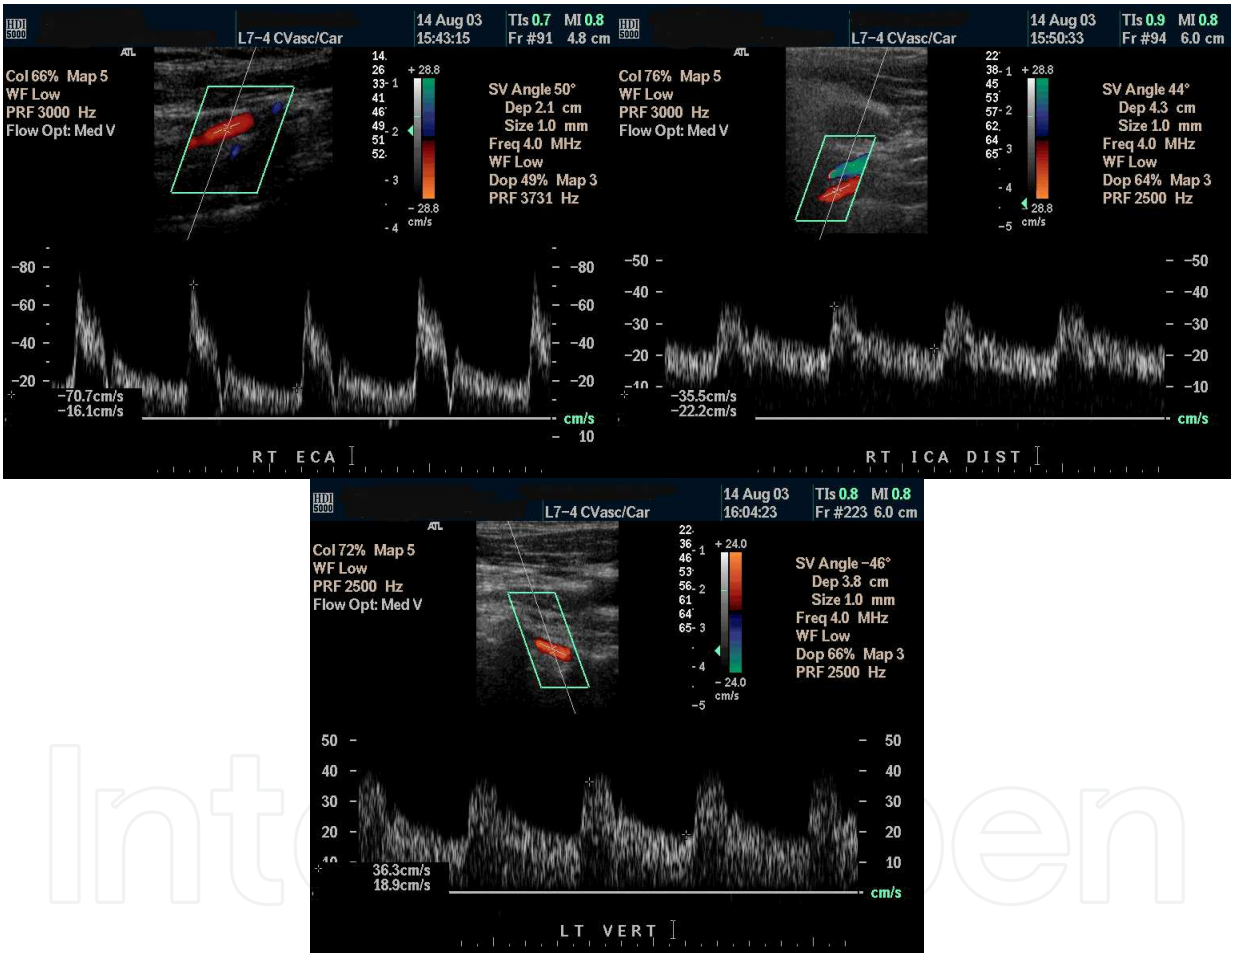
From left to right, ultrasound examples of the ECA (left), ICA (middle) and VA (right). Note: 1) The ECA waveform should have a sharp upstroke and a low end-diastolic velocity, as it supplies a high resistance vascular bed. ECA may have a flow reversal component (flow below the baseline) in late systole or early diastole; 2) ICA waveform should have a more gradual upstroke (slower acceleration) in systole, and an elevated end-diastolic velocity. This is because it supplies a low resistance vascular bed (i.e., the brain). Thus flow should be above the baseline for the entire cardiac cycle; and 3) The VA waveform should have a gradual upstroke and relatively high end-diastolic velocity as it also supplies a low resistance vascular bed.
